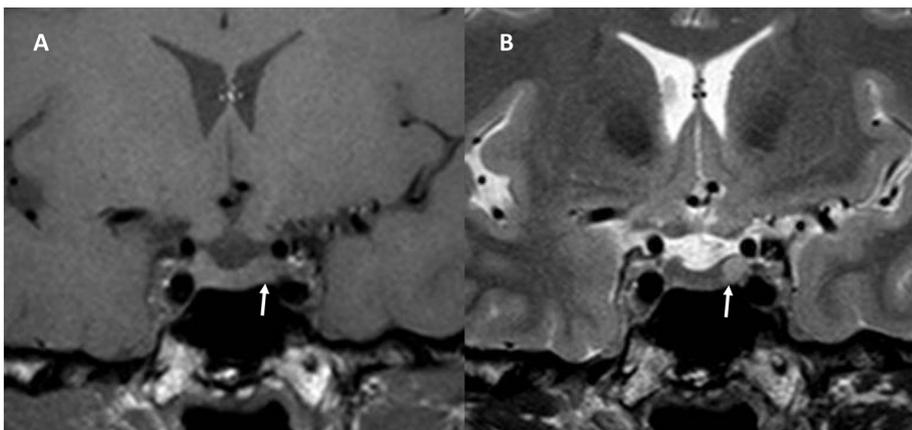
Microprolactinoma. The microprolactinoma is not visible (isointense) (white arrow) on MRI T1W coronal section (A) and becomes visible as an hyperintense lesion (white arrow) in the left part of the pituitary on T2W coronal section (B).
